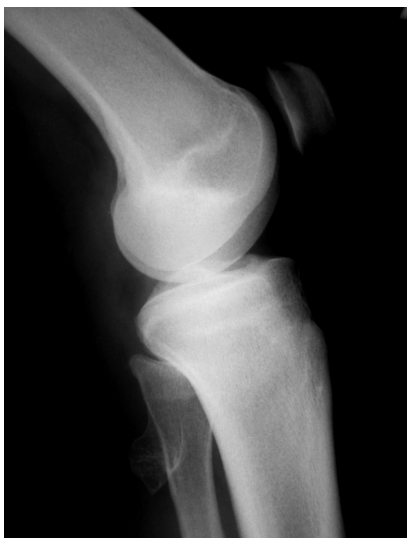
An x-ray scan showing the bone tumor in the area of the fibular head
